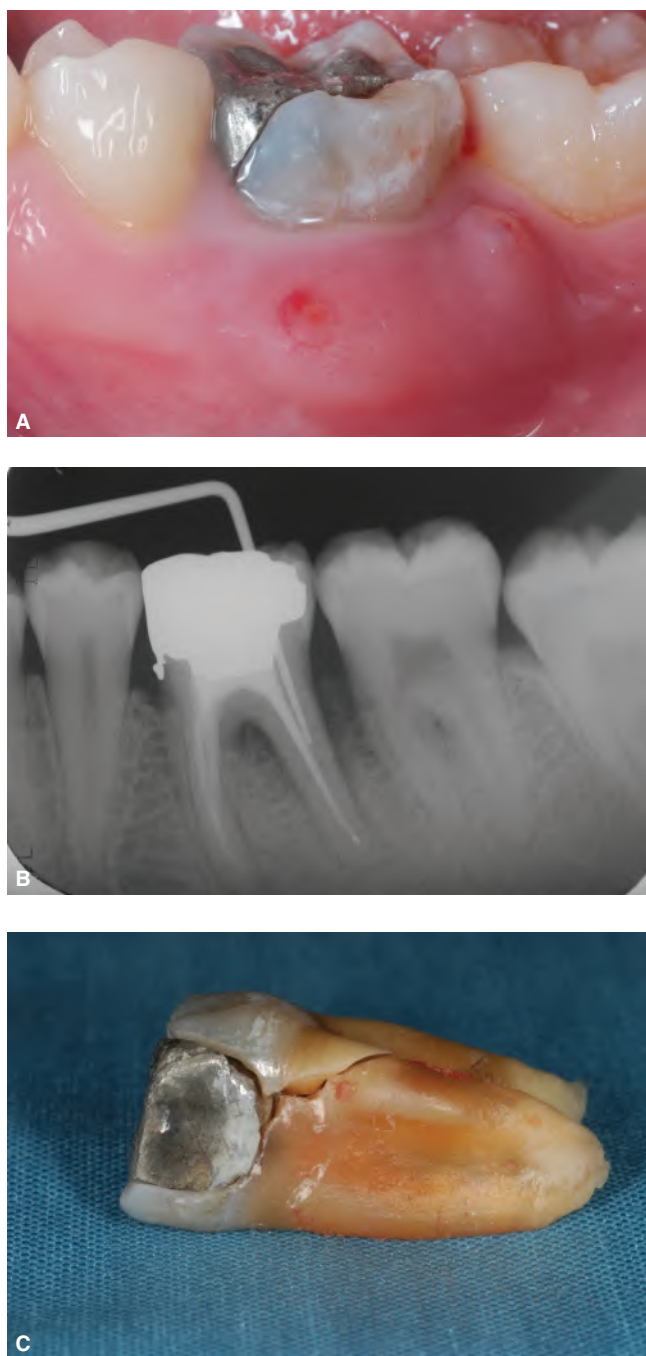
A. Buccal view of an endodontically treated mandibular left first molar without cuspal coverage reveals a dental fistula. B. Pre-operative radiograph showing a deep, isolated, and narrow periodontal pocket. C. Extracted tooth showing the fracture extending down both roots. (Reprinted with permission from Baba NZ.³³¹)
